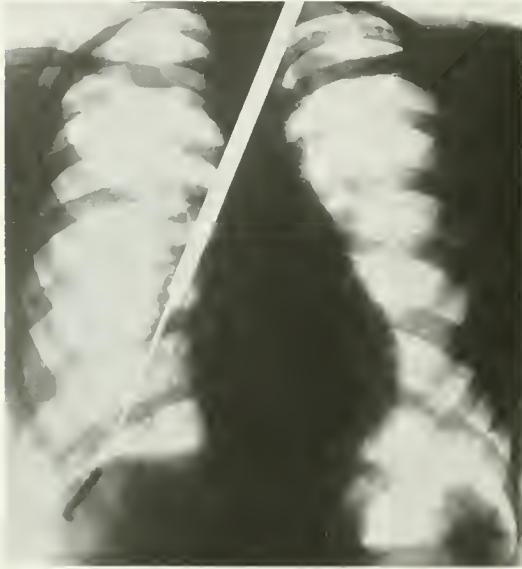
Girl, aged nineteen, "swallowed" a beauty pin ten years before. Diagnosed tuberculosis, because of hemorrhages. Had been examined repeatedly with the fluoroscope, but nothing found. An x-ray plate showed the pin to be lying below the dome of the diaphragm, anteriorly. The bronchoscope was passed as far as possible, which was still six inches from the pin. A pair of forceps were then passed through the bronchoscope and guided toward the foreign body, by means of two fluoroscopes working at right angles. Pin removed in four minutes from time bronchoscope was passed. Hemorrhages ceased at once, and patient made prompt recovery.
